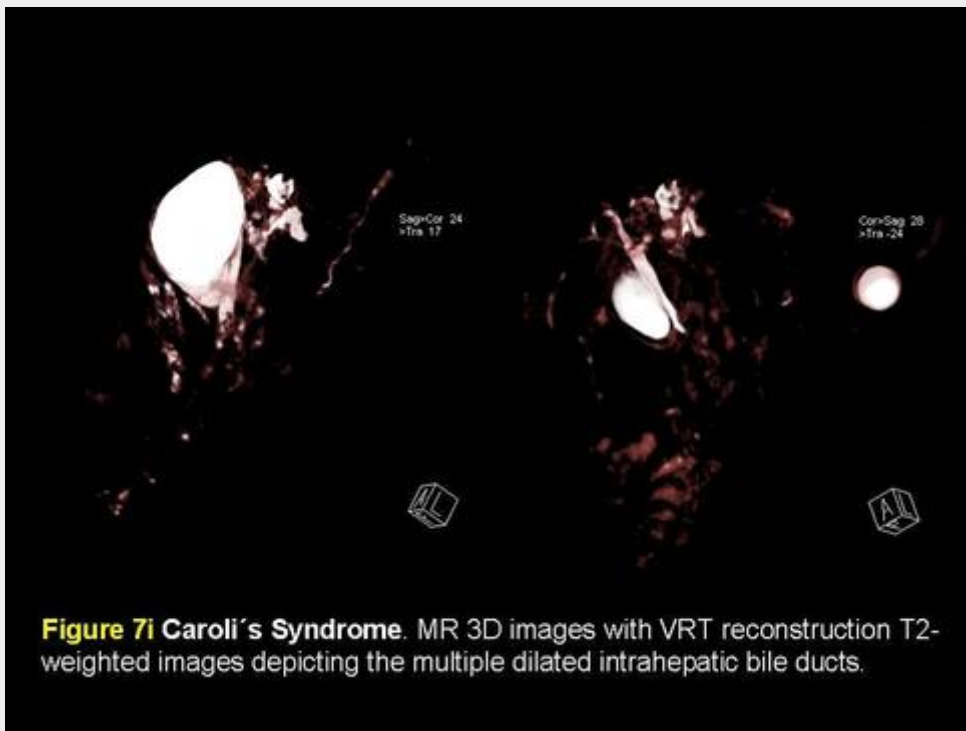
Caroli's Syndrome. MR 3D images with VRT reconstruction T2-weighted images depicting the multiple dilated intrahepatic bile ducts.
